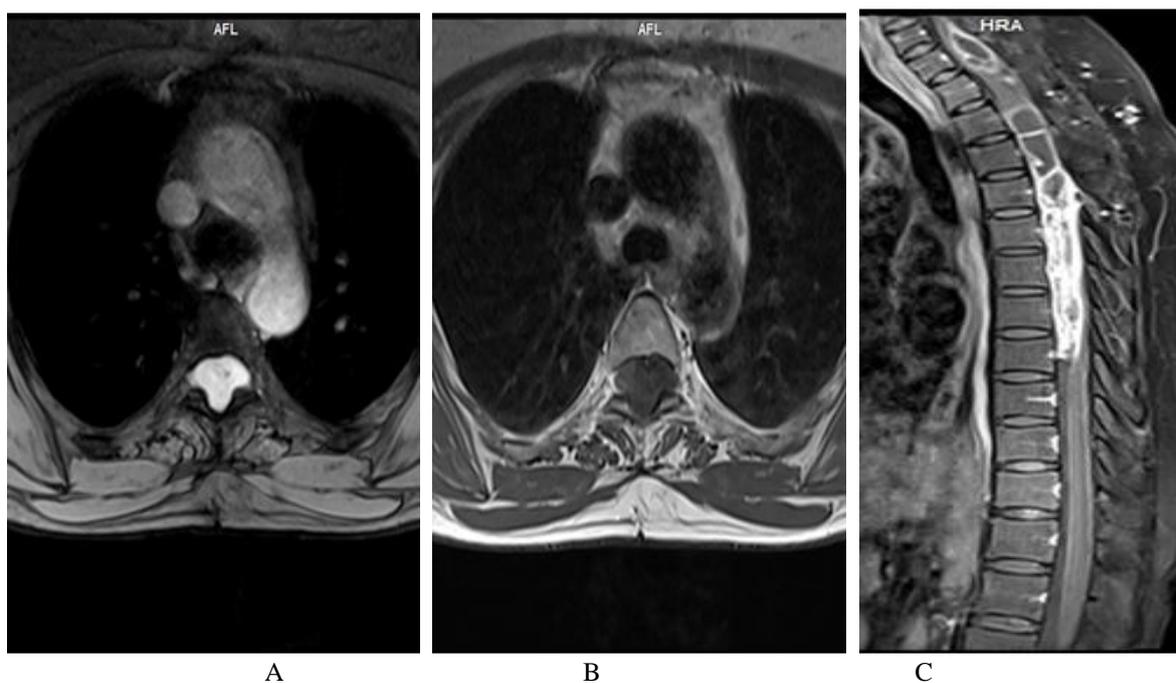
MRI of cervical spine of a 42 years old female
